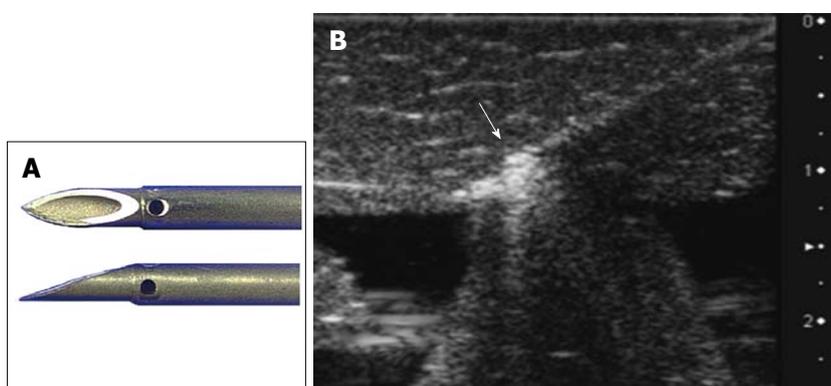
Vascular needle with four side holes, each 0.4 mm in diameter, drilled at 4 mm from the tip of the needle. A: Needle tip, shaft. The side holes are covered by the outer sheath. B: Corresponding ultrasound image. The arrow indicates the needle tip with side holes.
